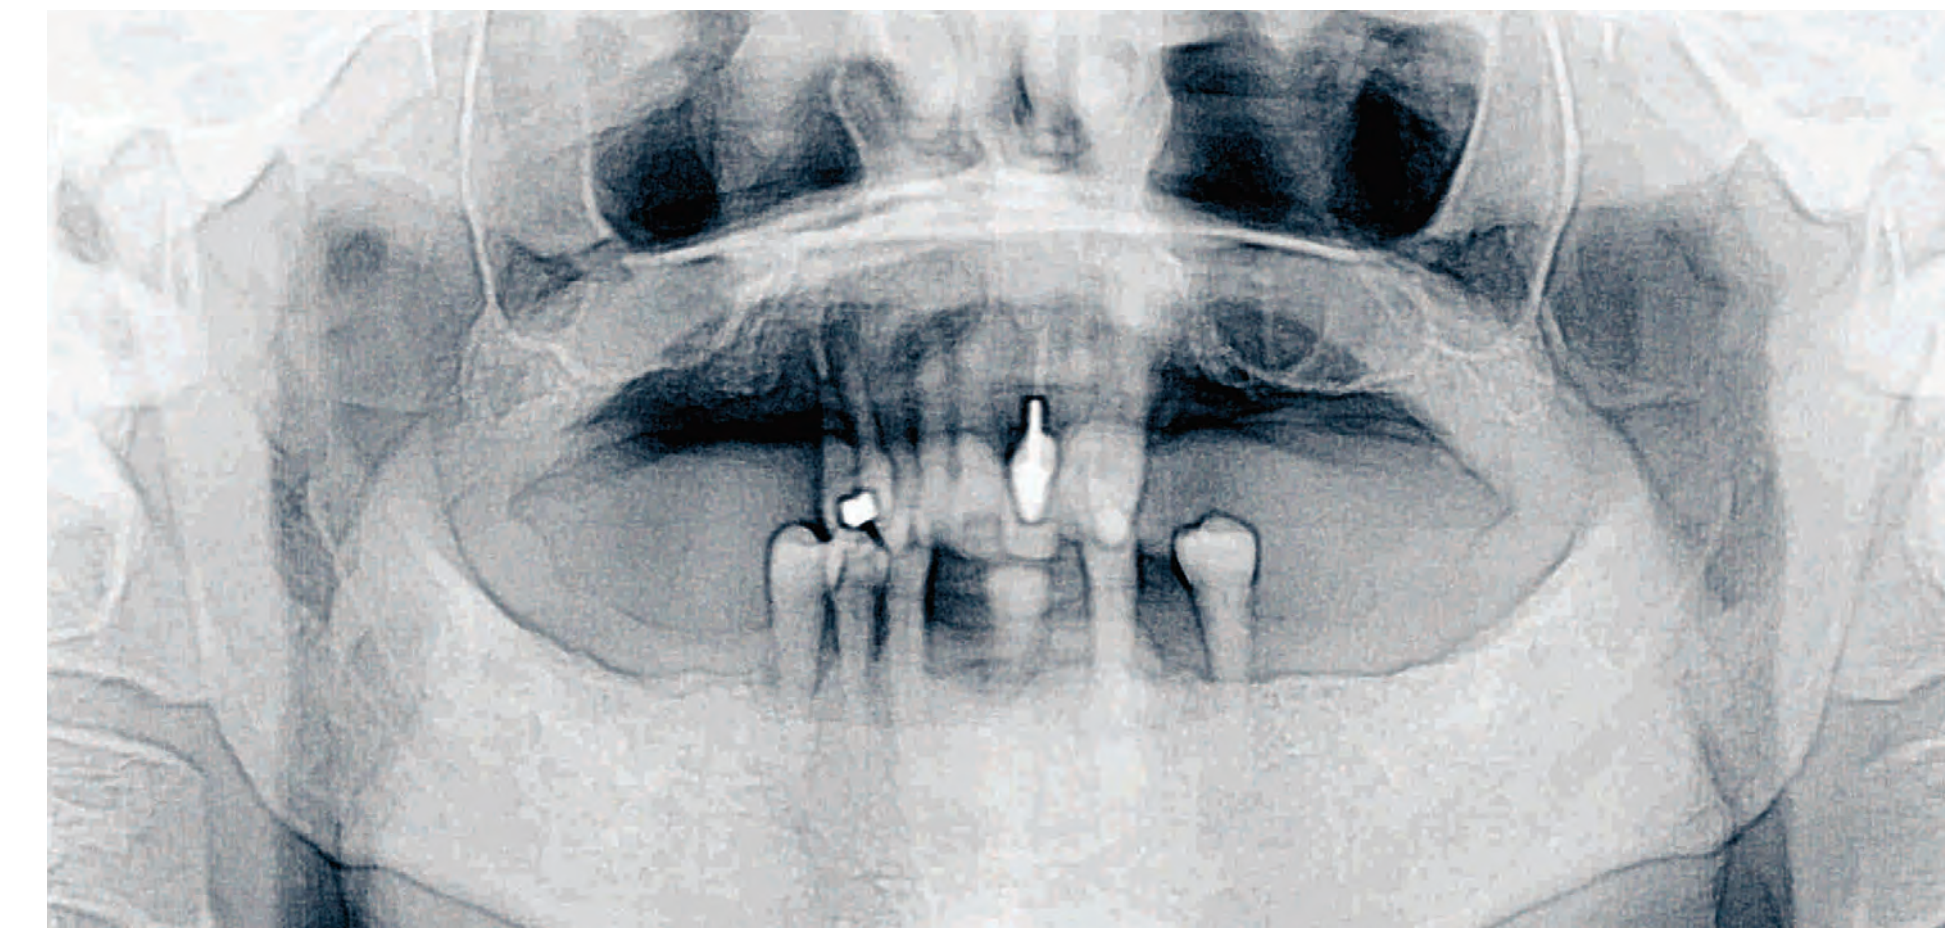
X-ray prior to graft placement, with pneumatised sinuses evident
